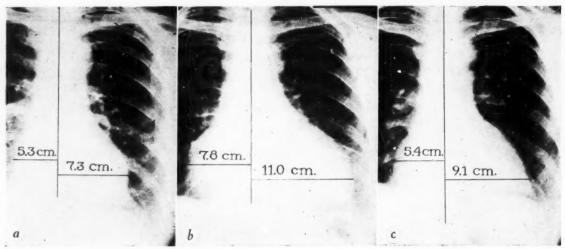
Roentgenograms of thorax delineating heart shadows before and after cyanate intoxication. a, June 5, 1944, one year before intoxication. Slightly enlarged heart commonly seen in patients who have essential hypertension. b, June 20, 1945, in the course of intoxication. Relatively a much larger heart shadow than in a. c, August 16, 1945, after recovery from intoxication. Relatively a much smaller heart shadow than in b and approximating that in a.
